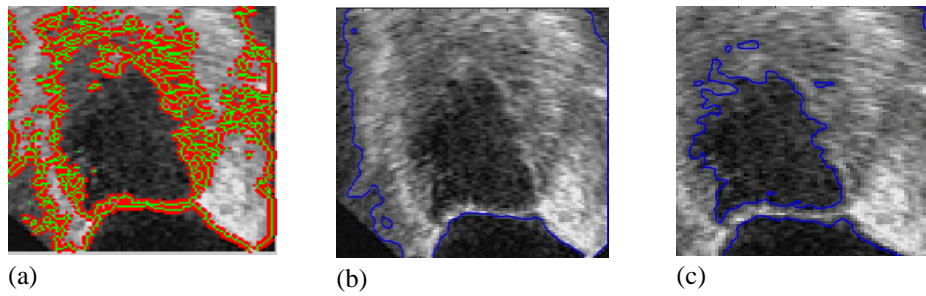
Experiment of an ultrasound image of a liver. The final results using the C–V, SGLACM, and proposed methods are shown in the first, second, and third columns, respectively. The parameter of $\alpha=0.1$ and σ is 5.
